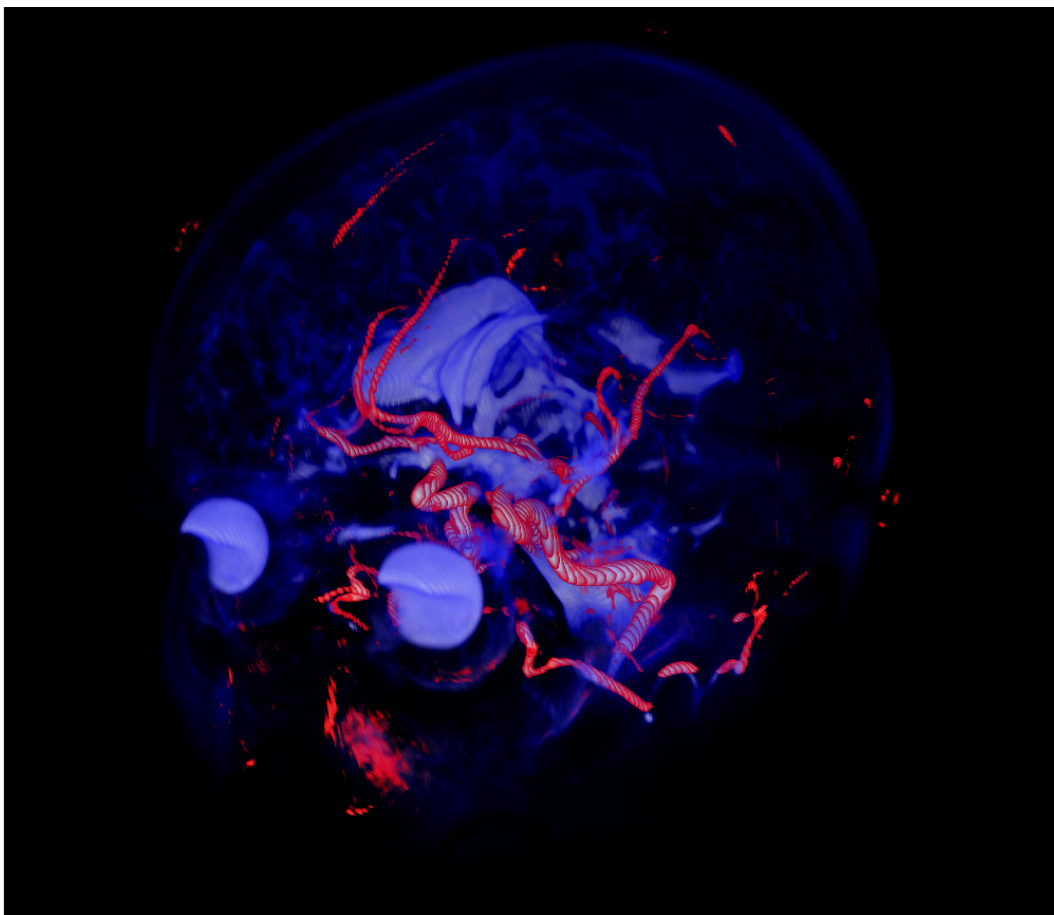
Dataset Tumor1. Volume renderings of MRI T2 (*blue*) and MRA (*red*).
